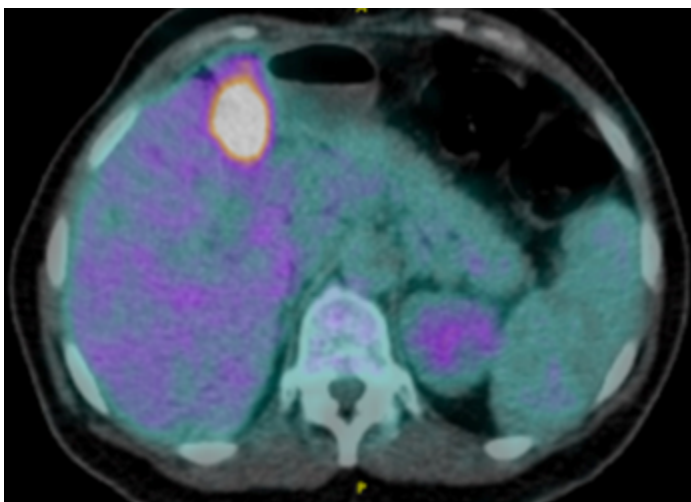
Focal intense FDG uptake anterior to the right hepatic lobe corresponding to an ill-defined soft tissue thickening inseparable from the hepatojejunal anastomosis with SUVmax 12.6, suspicious for locally recurrent disease.
